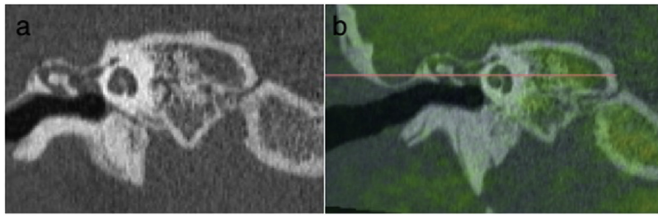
(a) Coronal CT and (b) fusion images and DWMRI (not shown) all did not confidently detect the small cholesteatoma at the anterior epitympanum.
